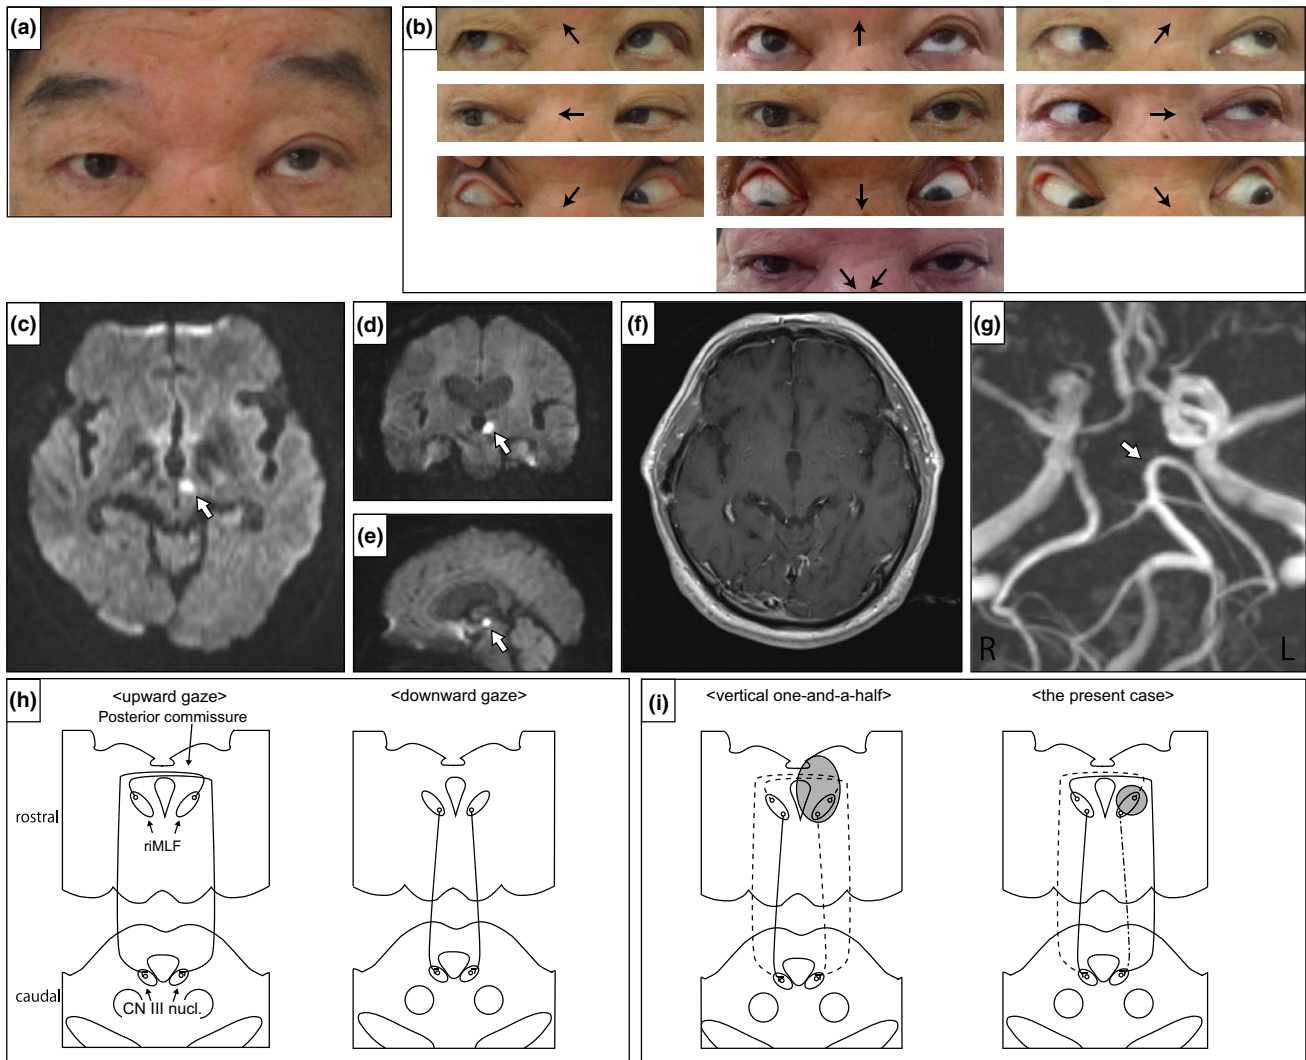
The left eye assumes a 10° position upwards in a straight ahead gaze (a) and mild downward gaze palsy (b), while the right eye shows evident upward gaze palsy (b). Convergence was absent (b). DWI images of a brain MRI, showing a small thalamosesencephalic stroke (c–e, arrows) without Gd enhancement (f). Brain MRA showing no evident stenosis of the basilar artery or left PCA (g, an arrow). Hypothesis of vertical eye movement (h): riMLF controls contralateral upward and ipsilateral downward gaze. Classical VOHS (i, left) involves bilateral upward and ipsilateral downward gaze (dotted lines) by a thalamosesencephalic lesion (left eclipse). The present case (i, right) involved only contralateral upward (dotted lines) and ipsilateral downward gaze (chain lines) due to a small thalamosesencephalic stroke (eclipse).
